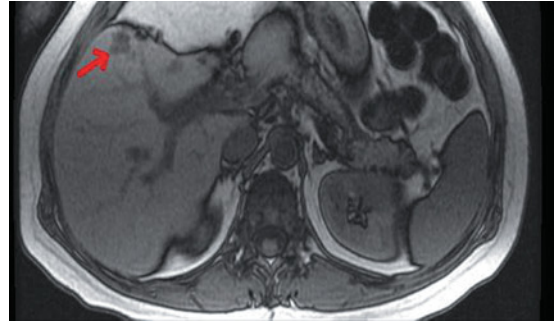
Non-contrast computed tomography scan obtained in 35-year-old woman with longstanding oral contraceptive use. Small hypodense mass consistent with adenoma (arrow).
